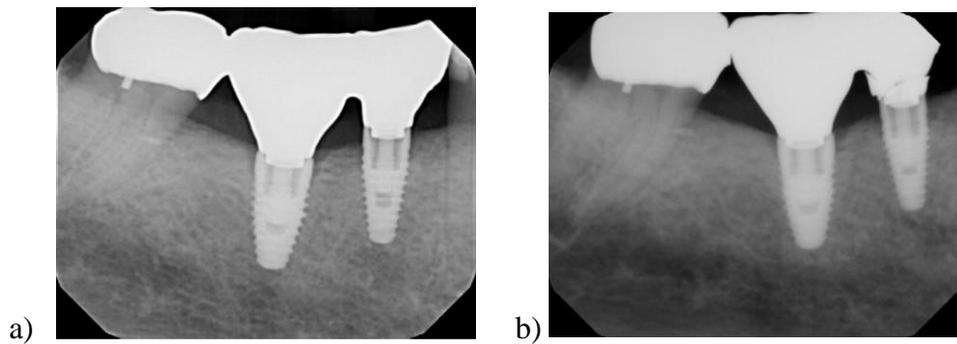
Radiographs depicting splinted metal-ceramic implant crowns placed in the Dr. Gerald Niznick College of Dentistry in November 2017 (a) and the resulting fracture of ceramic on tooth 45 in March 2018 (b).
